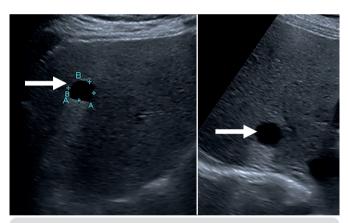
Simple cysts on ultrasound (arrows): anechoic, homogeneous, sharply delimited, and with posterior reinforcement.
